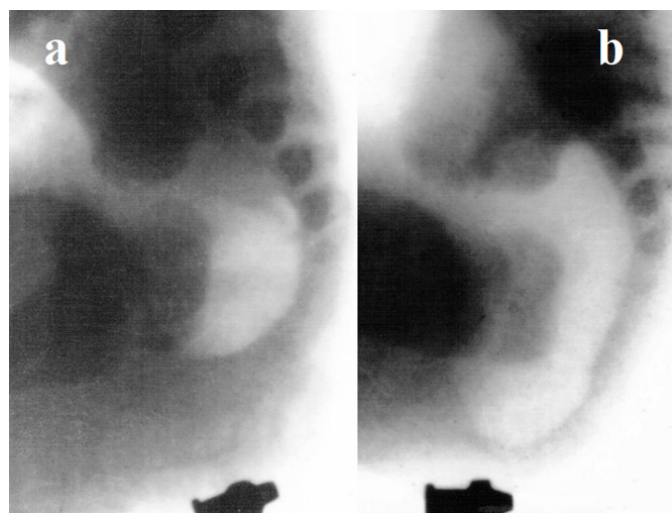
Radiographs of a newborn with ARM without fistula were performed horizontally. A radiopaque marker was glued to the anal dimple. (a) At rest, (b) During abdominal compression, the gas approached the marker. The distance between the marker and the intestine is the thickness of the skin and subcutaneous tissue
